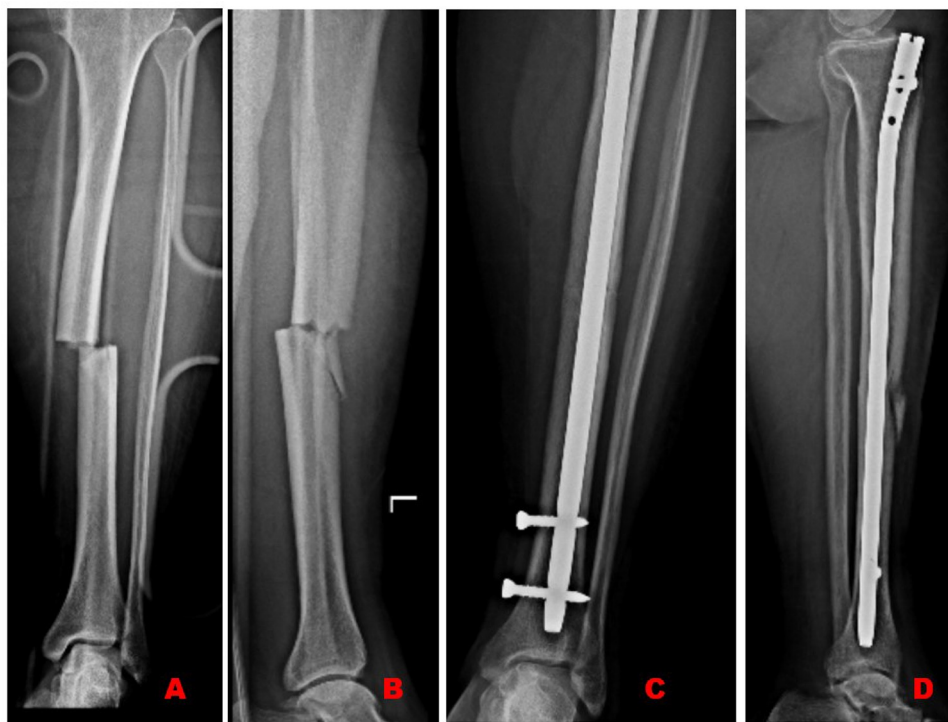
Radiographs of a 29-year-old man with tibial shaft fracture (A, B) managed by dynamic intramedullary nailing united at 13 weeks (C, D).
